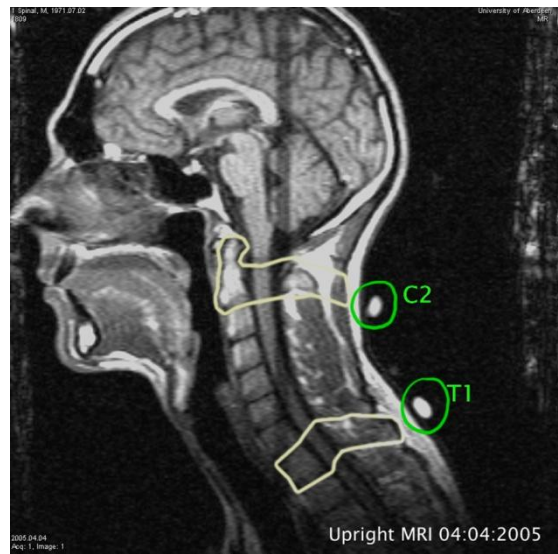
Fonar Upright MRI scan with markers
